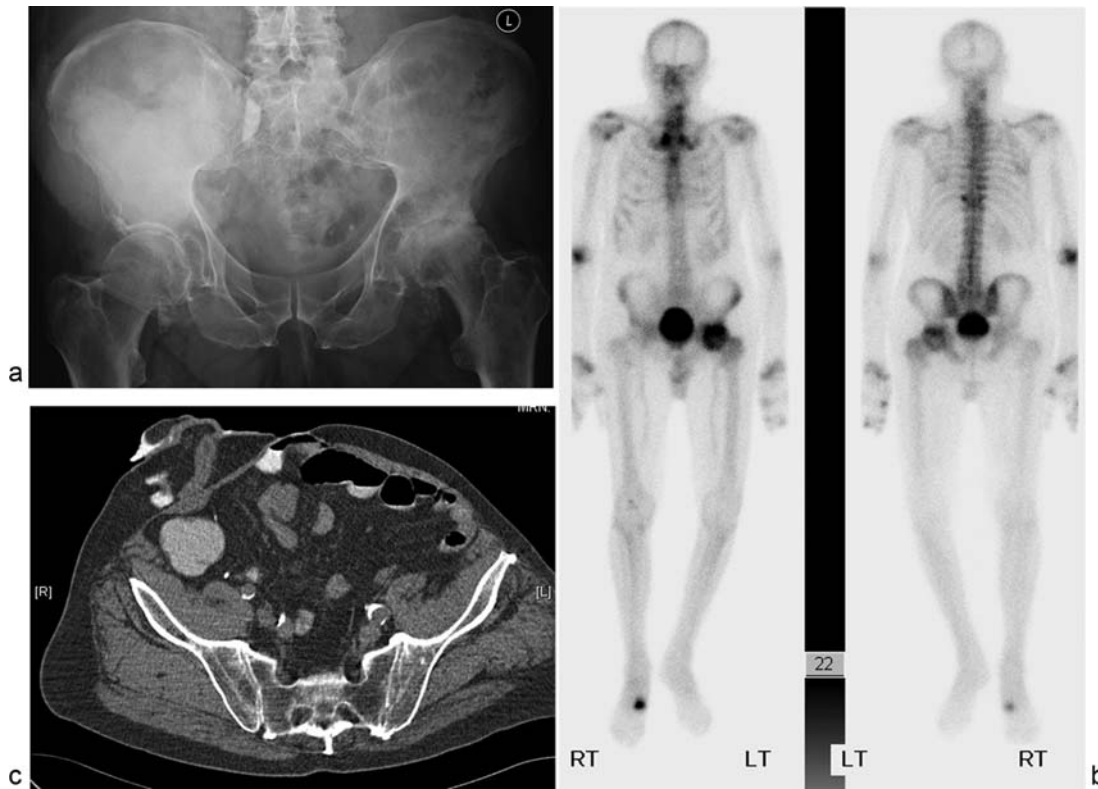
(a) Anteroposterior radiograph of the pelvis of an elderly man referred to an orthopaedic oncology unit for investigation of a sclerotic lesion in the right ilium that did not show increased activity on (b) the whole-body bone scintigraphy. (c) Axial computed tomography of the pelvis showed the right ilium to be normal and revealed that the apparent sclerosis was artifactual due to an overlying colostomy device. There was no relevant clinical information in this regard at the time of referral.
